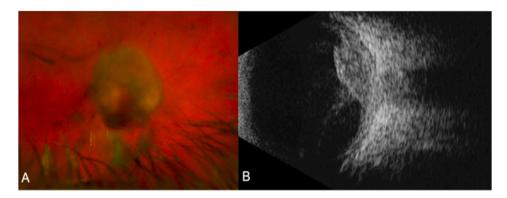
Final pseudo-color fundus photography (A) and B-scan Ultrasonography (B) of the Right Eye demonstrating improved vitritis and progression of the chorioretinal lesion into an abscess with areas of fibrosis. (For interpretation of the references to color in this figure legend, the reader is referred to the Web version of this article.)
